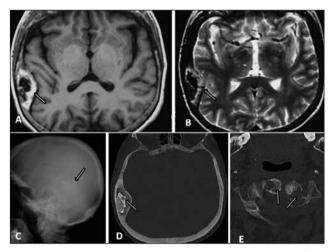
(A-E). Axial T1-weighted (W) spin-echo (SE) (TR/TE: 600/20ms) (A) and T2-weighted (W) turbo SE (TR/TE:4000/ 100ms) (B) show an expansive bony lesion with hyperintense (T1-W) and isointense (T2-W) periphery and dark center (arrows). The lesion has a mass effect on the temporal parenchyma. On lateral plain film of the skull there is thickened calvarium with increased trabeculation (C). Irregular contoured calcification is also remarkable (arrow). An axial noncontrast computed tomography (CT) imaging reveals a fusiform lesion that involves inner and outer tables and shows heavily calcified matrix in the squamous part of the right temporal bone (D, arrow). Wel-demarcated focal radiolucent lesions in C1 and C2 vertebrae were additionally observed (E, arrows).
